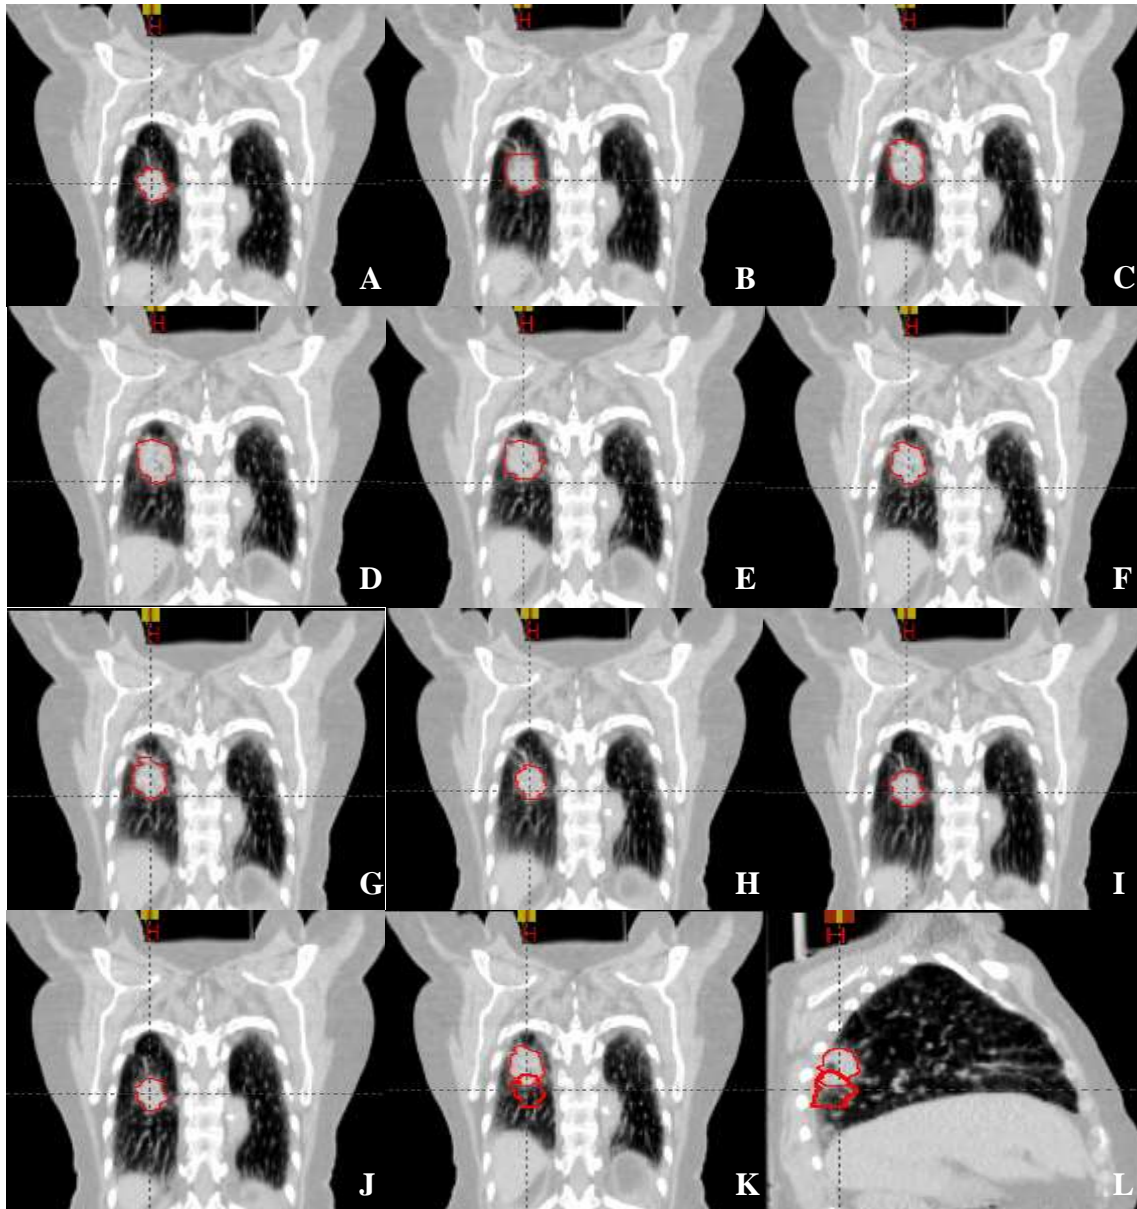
Tumour motion in a 4D-CT scan
